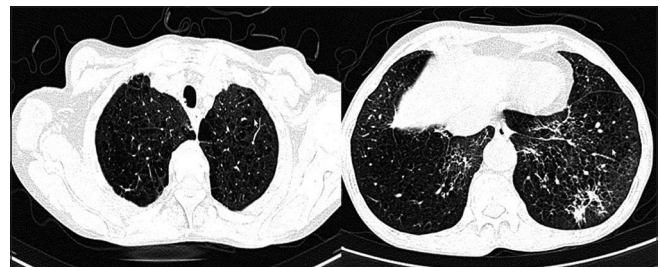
High-resolution computed tomography thorax (upper and lower lobe cuts) showing air-trapping, reticular, nodular shadows and tree in bud lesions bilaterally
